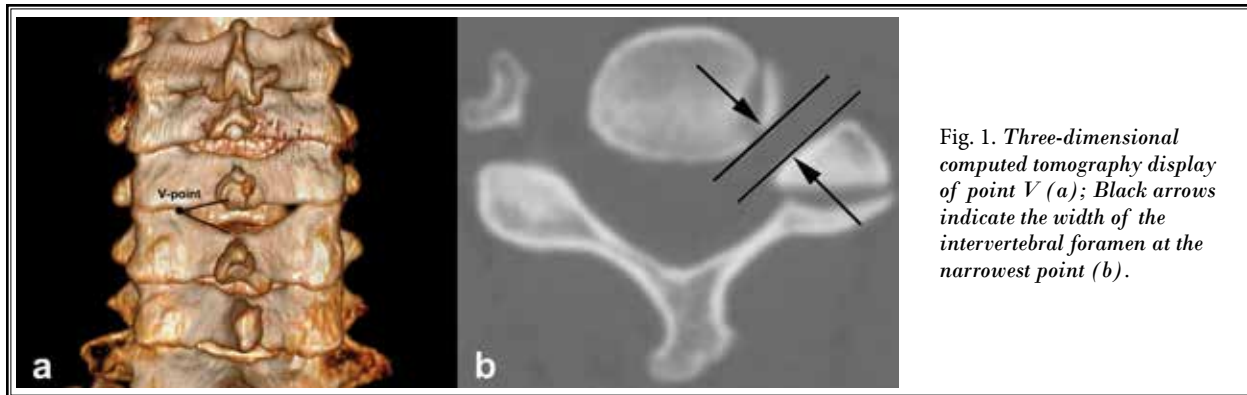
Three-dimensional computed tomography display of point V (a); Black arrows indicate the width of the intervertebral foramen at the narrowest point (b).
